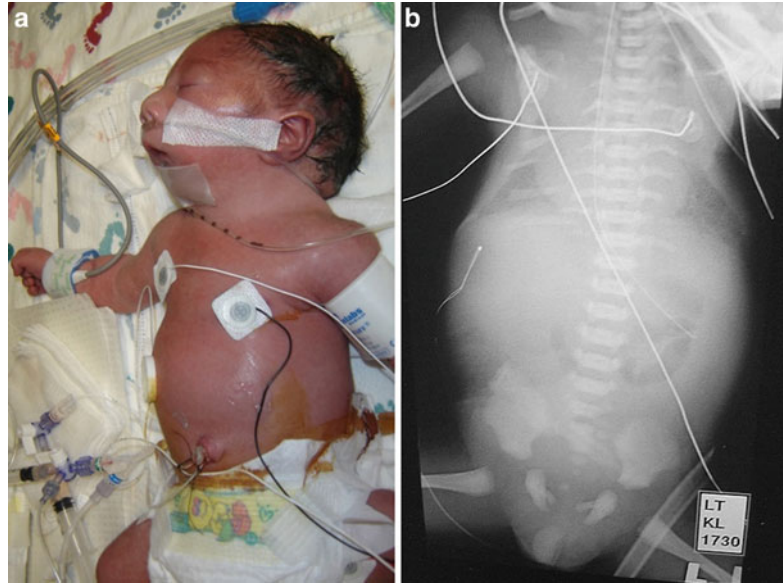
(a–c) A neonate presented with severe respiratory distress, requiring tracheostomy. He has severe retrognathia and a small chest. Radiographs showed
